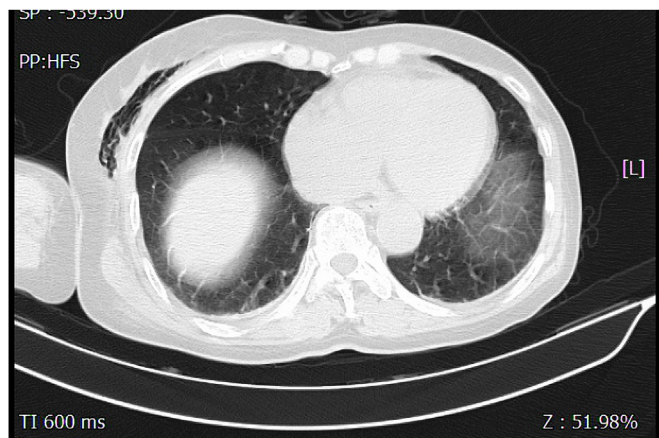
After 2 days, CT reexamination showed that pneumothorax and subcutaneous emphysema were almost vanished.
